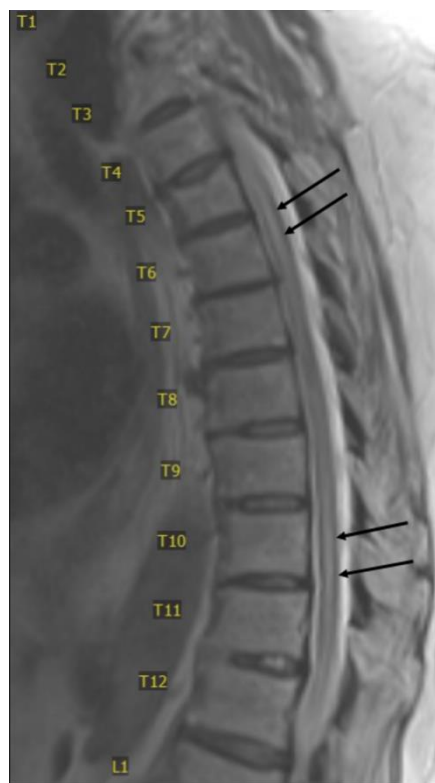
Axial T2-weighted MRI of the thoracic spine showing increased signal intensity within the spinal cord. MRI, magnetic resonance imaging.
